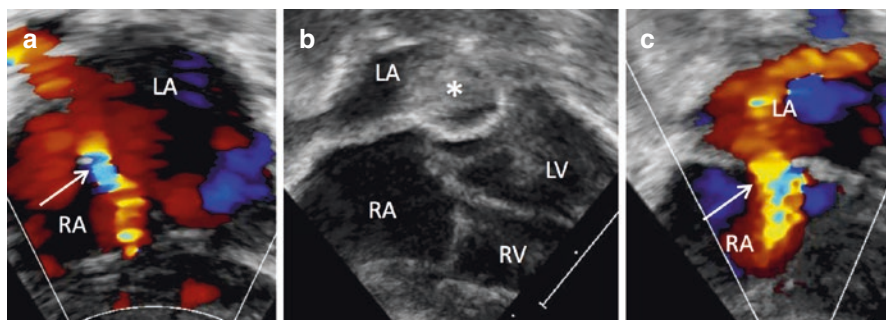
Balloon atrial septostomy in the subcostal view of transthoracic echocardiography. (a) At baseline, color Doppler imaging shows a small restrictive atrial communication (arrow). (b) A balloon (*) of septostomy catheter is inflated in the left atrium (LA). (c) In post-balloon atrial septostomy, there is larger unrestrictive atrial communication (arrow)
